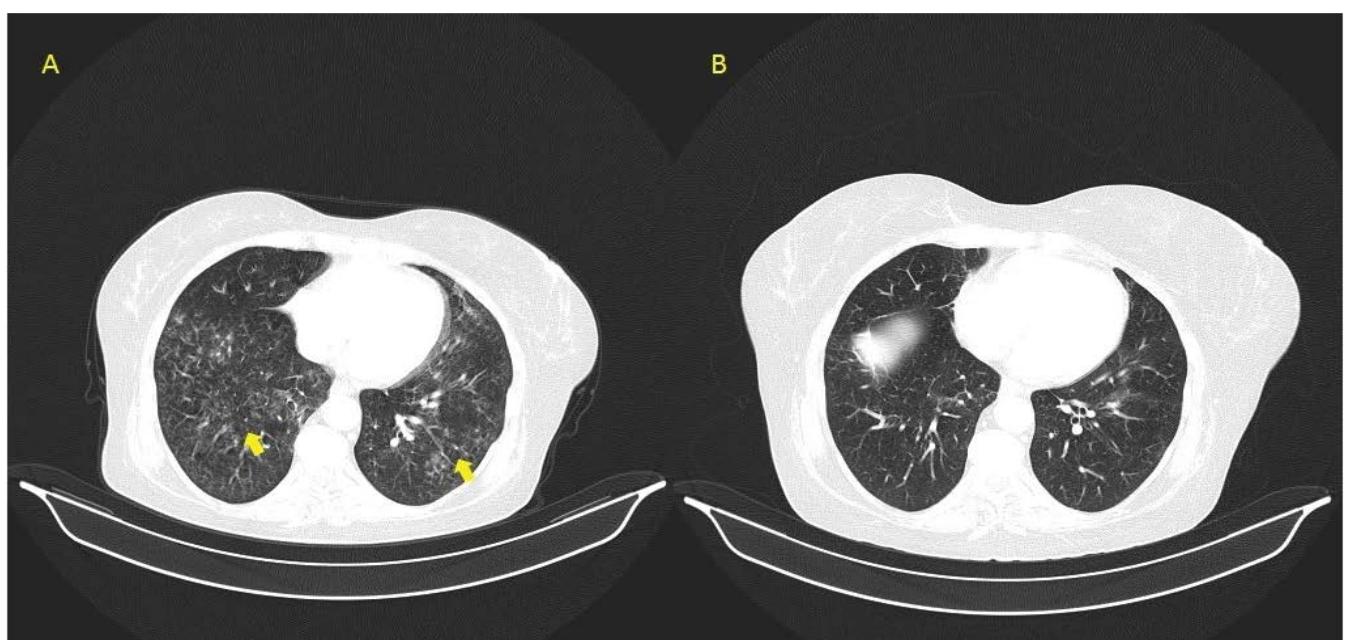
(A) CT scan showing bilateral interstitial infiltrates compatible with pneumonitis, (B) CT scan showing resolution of the bilateral infiltrates two months after corticosteroid treatment.
